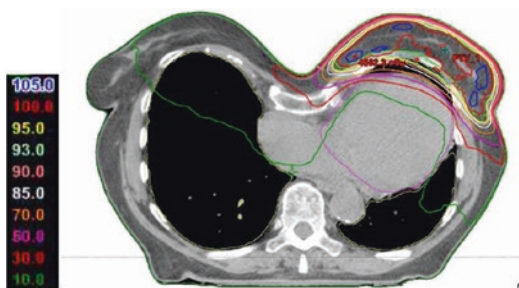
Axial view of planning CT showing the dosimetric distribution (% isodose line of prescribed dose)
